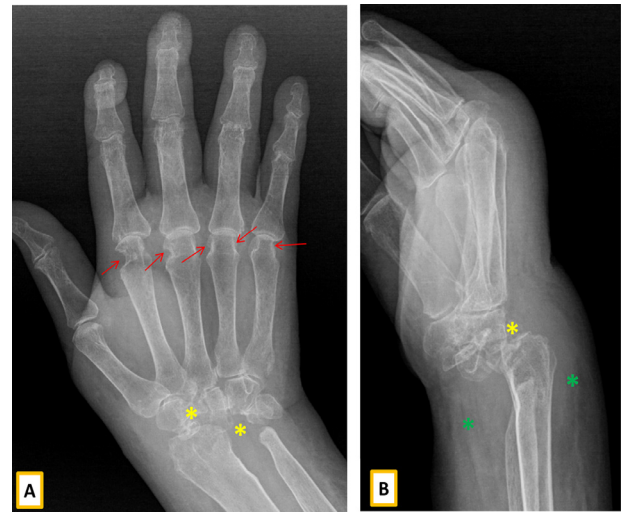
(A) Frontal and lateral (B) Radiographic views of the right wrist and hand, showing generalized osteopenia and marginal erosions involving the MCP joints (red arrows) consistent with the diagnosis of rheumatoid arthritis. Destruction of the carpal and the distal radio-ulnar joint, with volar dislocation of the radio-ulno-carpal joint with debris, reflecting Charcot joint (yellow asterisks), with volar and dorsal wrist joint soft tissue swelling (green asterisks).
